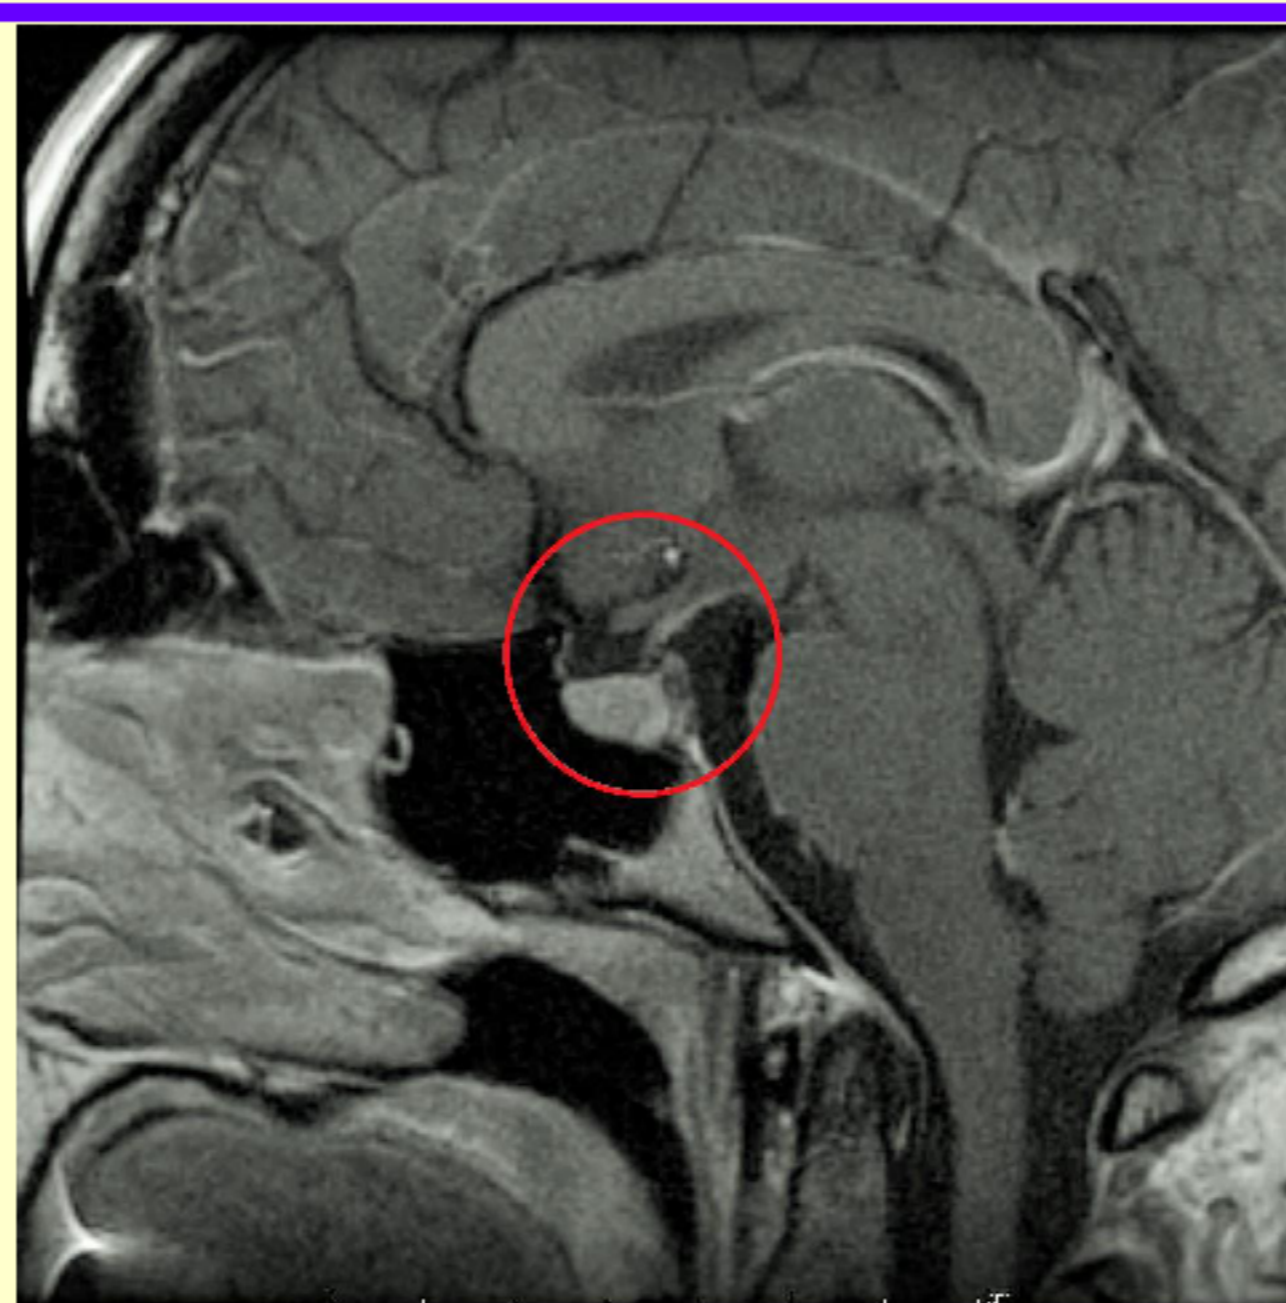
MRI Brain with thickening of the pituitary stalk
